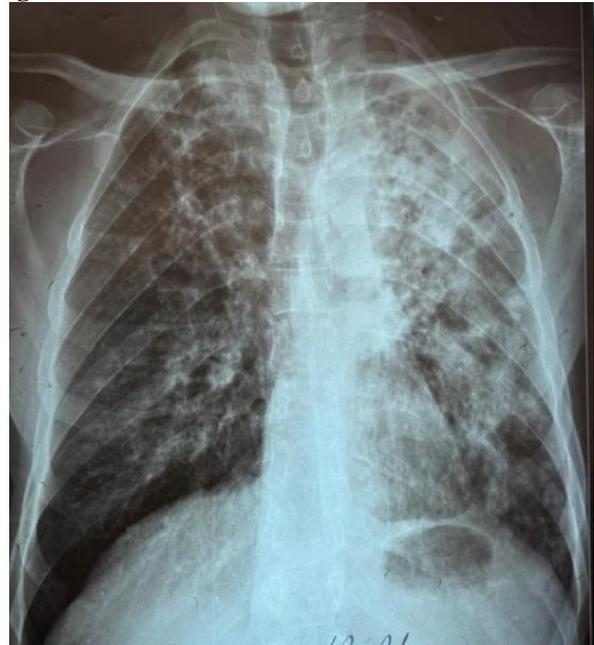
Chest radiograph showing diffuse bilateral nodular and micronodular infiltrates with cavitory lesions, consistent with pulmonary tuberculosis.
